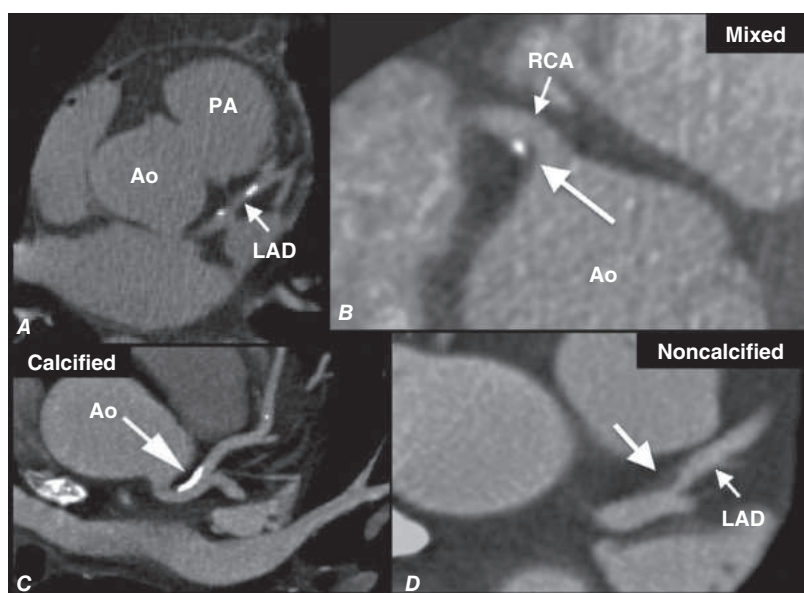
Examples of non-contrast- and contrast-enhanced coronary imaging with computed tomography (CT). A, Calcified coronary plaques in the distal left main and proximal left anterior descending coronary artery (LAD) in a noncontrast cardiac CT scan. Calcium deposits are dense and present as bright white structures on CT, even without contrast enhancement. B, C, and D, Different types of atherosclerotic plaques on contrast-enhanced CT scans. Importantly, noncalcified plaques are evident only on contrast-enhanced CT scans. AO, aorta; PA, pulmonary artery; RCA, right coronary artery.
